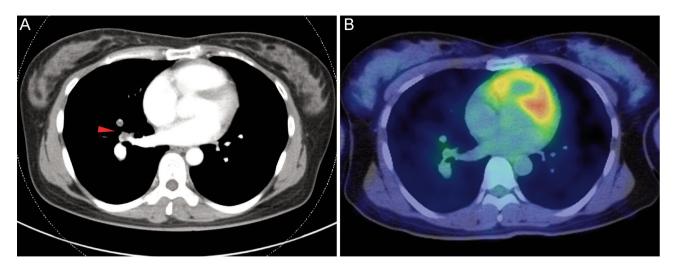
Imaging findings at the first visit to our hospital. (A) Enhanced computed tomography (CT) shows a poorly enhanced lesion in the right lateral basal pulmonary artery (arrow). (B) F-18-fluorodeoxyglucose positron emission tomography/CT. The SUV of the lesions is as low as 3.4. SUV: Standard uptake value.
